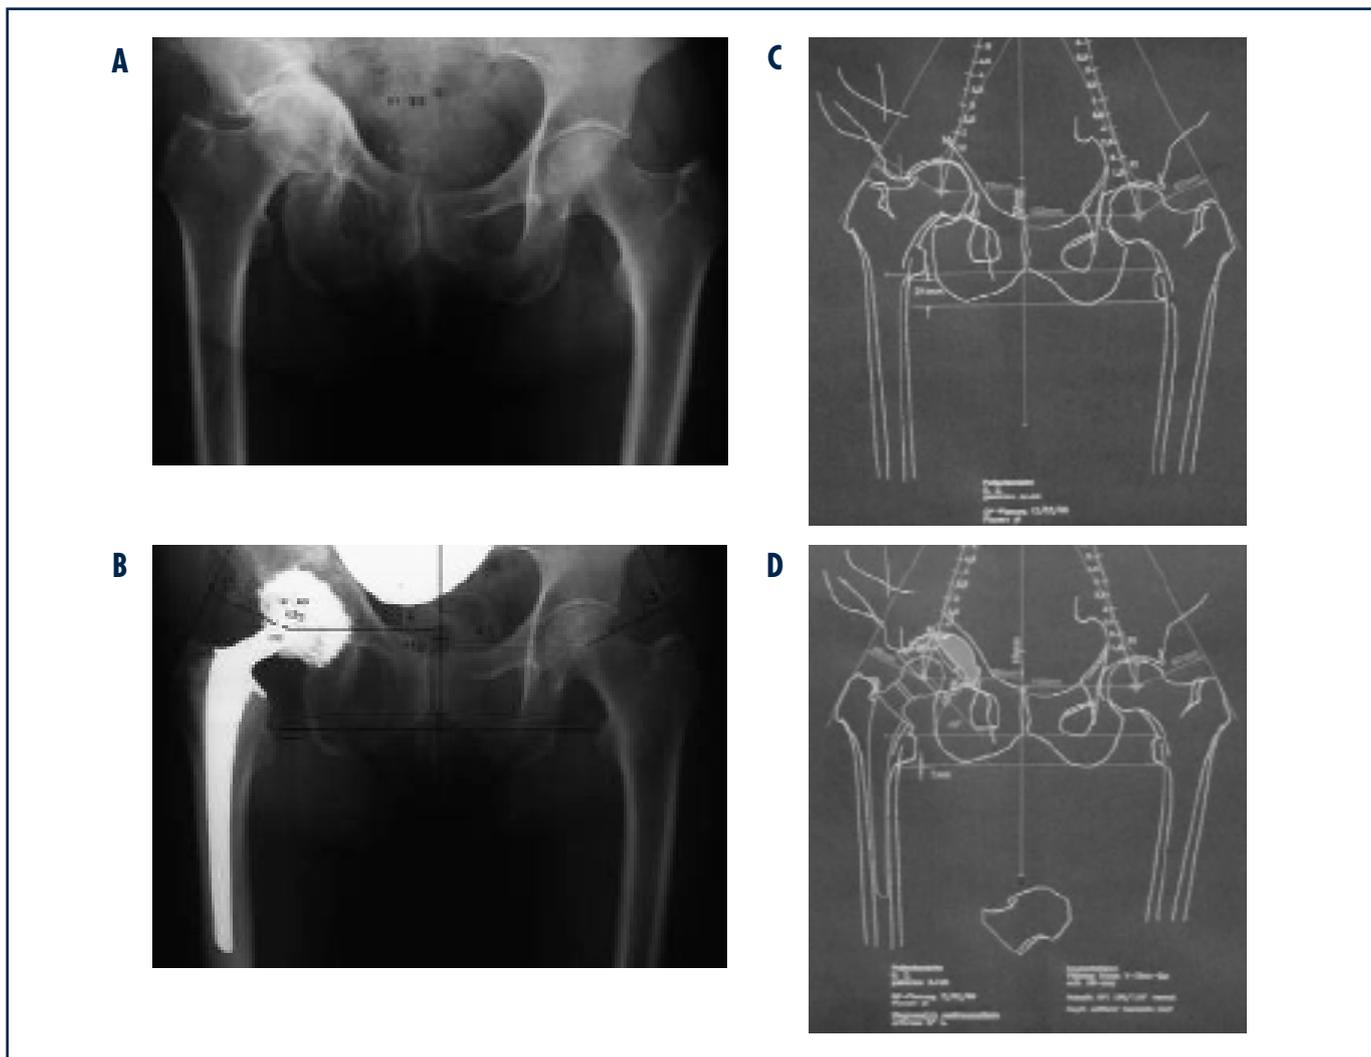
(A-B). Pre- and post-operative radiographs and corresponding planning output.
